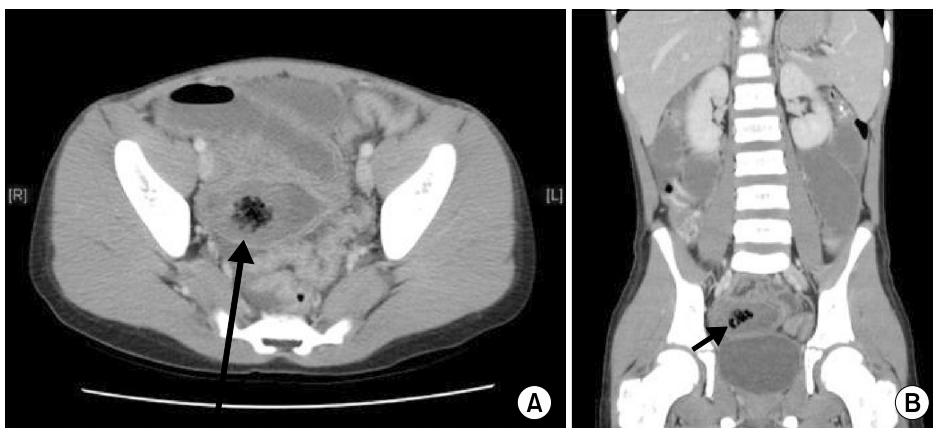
Abdominopelvic computed tomography scan (A: axial view, B: coronal view) showing the 1.8 cm-sized round intraluminal hypodense mass (black arrows) with a 'mottled gas' pattern in the lumen of distal ileum.
